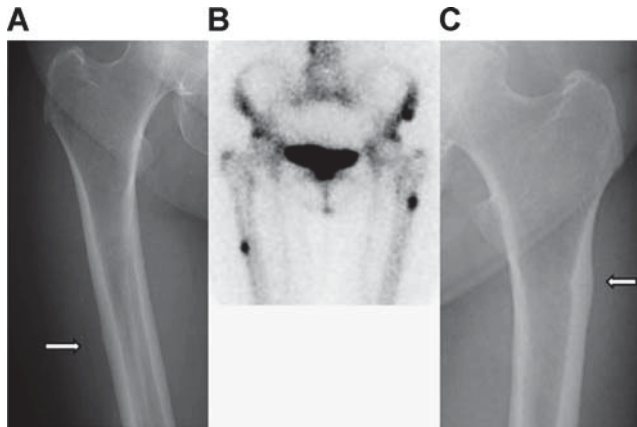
Conventional AP radiographs of the right (A) and left femurs (C) demonstrate subtle focal cortical thickening on both periosteal and endosteal surfaces, as well callus on the periosteal surface (*arrows*), whereas bone scintigraphy (B) demonstrates focal increased radionuclide uptake in the corresponding proximal lateral femoral cortices, findings consistent with early, evolving, bilateral femoral insufficiency fractures. (*Courtesy of Piet Geusens, MD.*)
